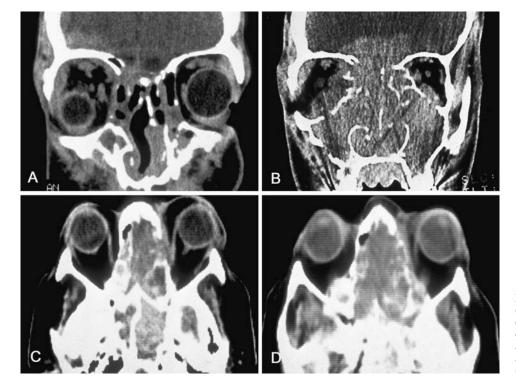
Two rapidly expanding esthesioneuroblastomas originating from the olfactory cells of the nose and involving the adjacent perinasal sinuses, orbits, and the brain. (A,B) Coronal and (C,D) axial CT images.
